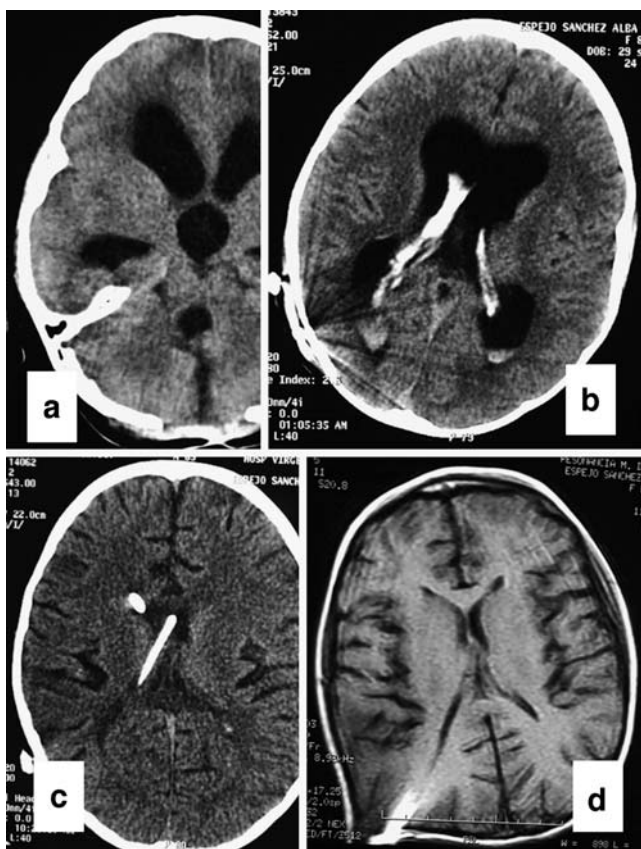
Neuroimaging studies of patient 1: a CT depicting severe post-haemorrhagic hydrocephalus; b CT obtained at his second admission for shunt obstruction; c CT taken after neurological deterioration following ventricular catheter replacement; d CT performed after removal of the ventricular drainage showing a residual intra-ventricular clot
